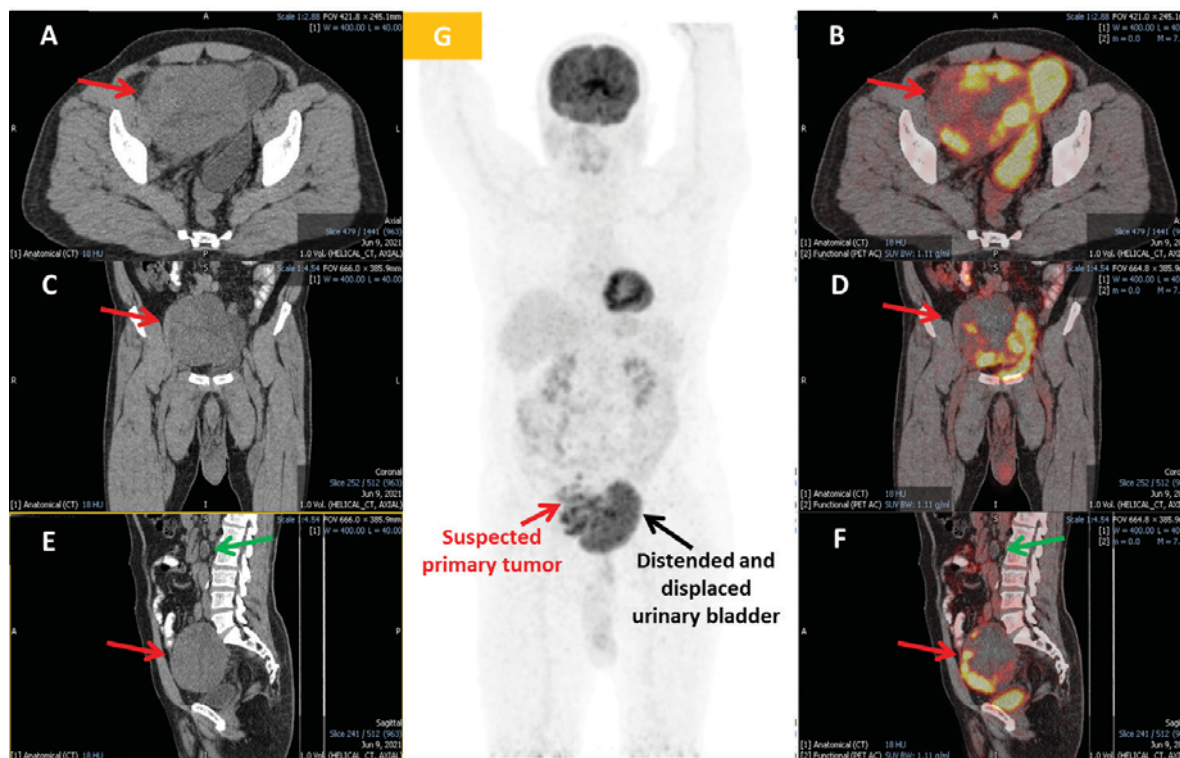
¹⁸F-FDG PET/CT images (A-B: axial; C-D: coronal; E-F: Sagittal and G: MIP) red arrow showing a large hypermetabolic heterogenous right pelvic mass and displacing the urinary bladder and absent right testis in scrotal sac. Green arrow in section E-F showing non-FDG avid aortocaval node.
